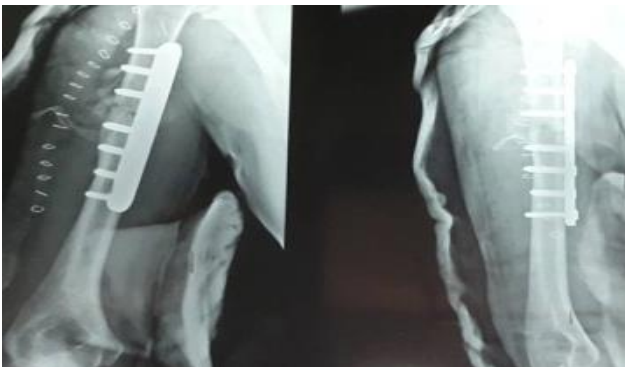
X-ray anterolateral approach.
